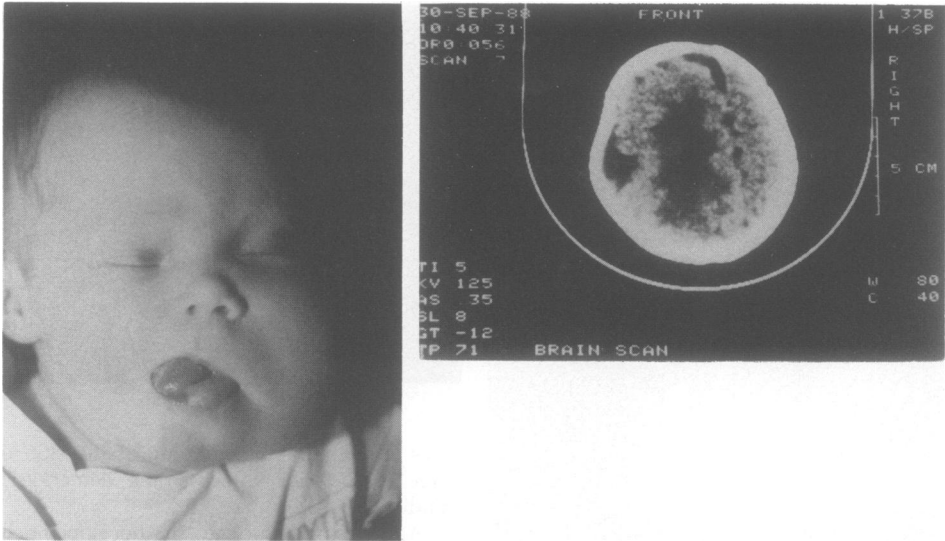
Case 2 newborn and CT scan at 3½ months.
